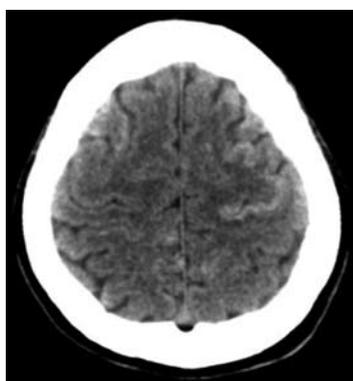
Fifty-three hours after the second TACE, a non-contrast head CT showed multiple high-attenuating spots and patch-like lesions in bilateral parietal and frontal cortex, suggesting the lipiodol desposition.
